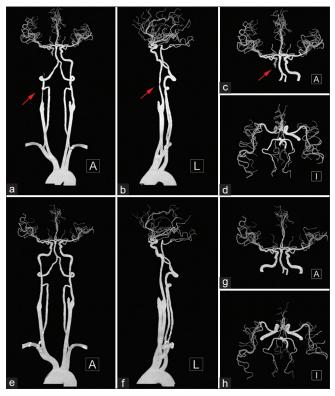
The computed tomography angiography at 4 months after surgery. (a-d) On admission, the occlusion of the right internal carotid artery (ICA) and the stenosis of the left ICA. (e-h) On follow-up at 8 days, bilateral ICAs were normal. The red arrow indicated the stenosis segment
